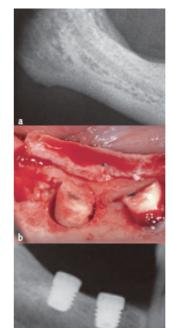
Treatment sequence of a patient with posterior mandibular edentulism randomly allocated to 5 mm-long implants: a) preoperative orthopantomograph: b) a trephine with a stop was used to prepare both implant sites: c) postoperative baseline periapical radiographs showing the two implants in place; d) the provisional acrylic crown was delivered 4 months after implant placement: e) radiograph taken at delivery of the provisional fixed dental prosthesis; f) 4 months after initial loading the definitive fixed dental prosthesis was delivered; g) periapical radiograph taken just after delivery of the definitive fixed dental prosthesis.
